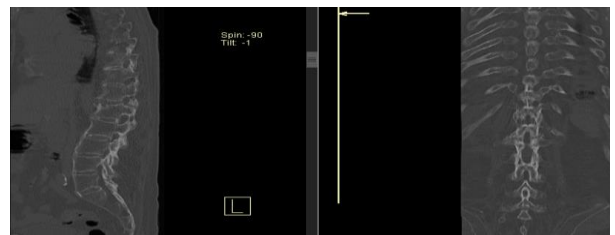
A. Preoperative CT - Non-union of Transdiscal Th12-L1 Fracture.
